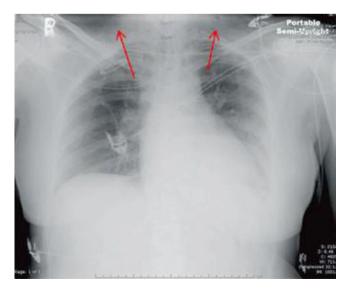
Subcutaneous emphysema (*red arrows*) in a patient with no other radiographic findings
